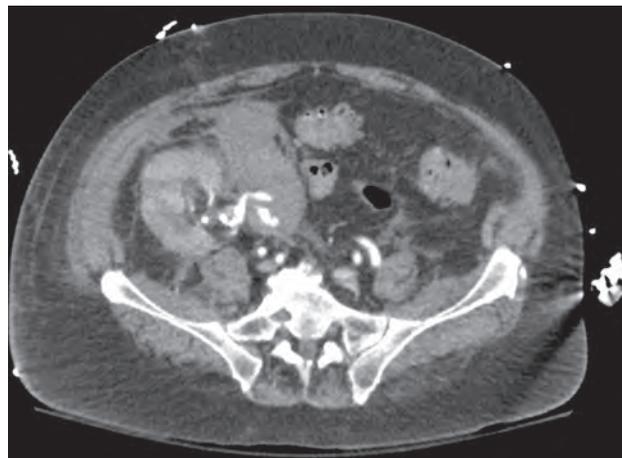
CT Abdomen with extravasation from transplanted renal artery
